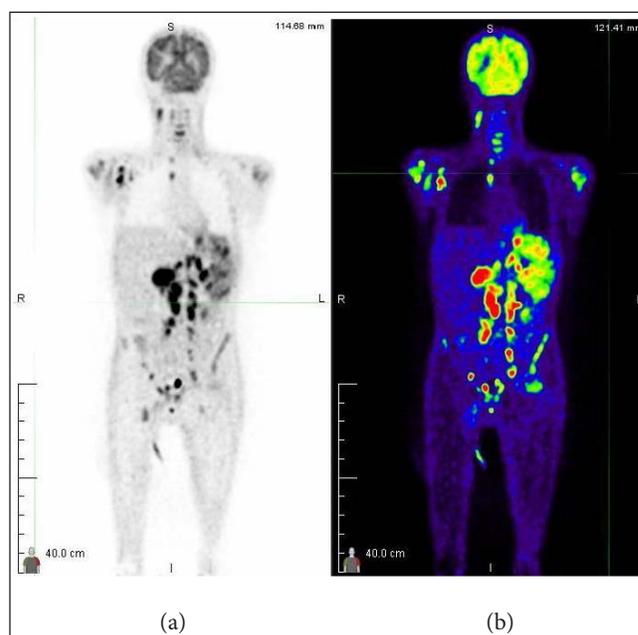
(a) PET-CT scan showed multiple lymphadenopathies in multiple regions. (b) PET-CT scan showed multiple hypermetabolic lesions in the bone marrow. PET-CT: Positron Emission Tomography and Computed Tomography.
